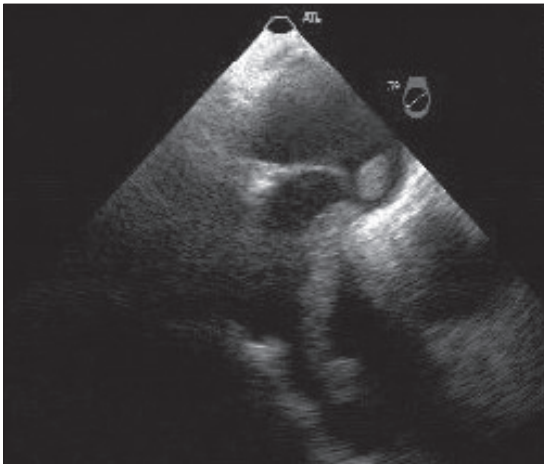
Transesophageal echocardiography view of a mobile thrombus extending from the right atrium to the left atrium through a patent foramen ovale and protruding in-to the left ventricle during diastole
